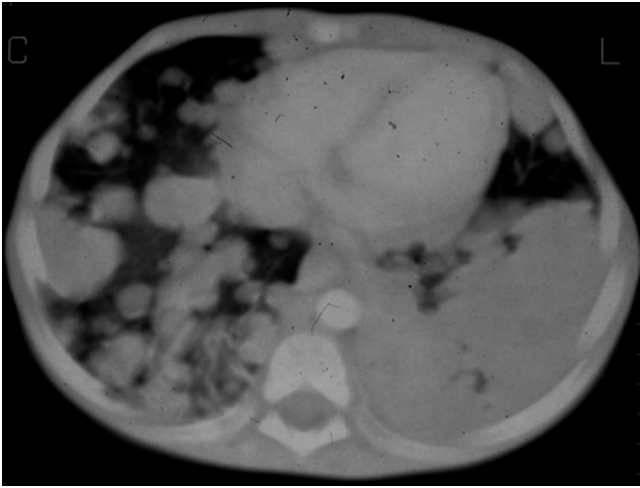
Axial CT image of a patient presenting with Wilms' tumour
